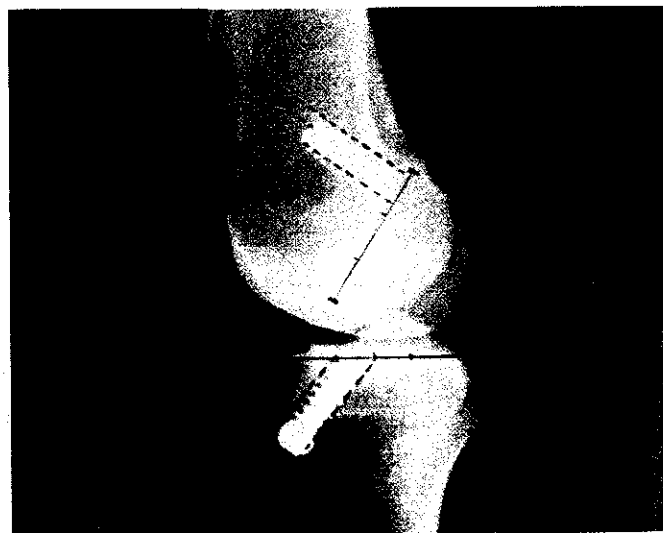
Post-operative lateral knee radiograph identifying screw placement
